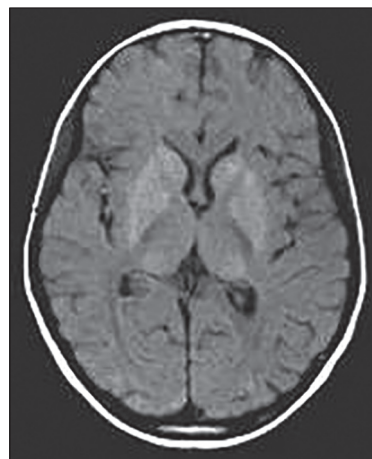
T1 weight magnetic resonance imaging (MRI) of a 27-year-old man who had a history of high grade fever with unconsciousness 3 years back, followed by symmetric Parkinsonism. MRI shows hyperintensities in bilateral caudate, globus pallidi, putamen and thalami
